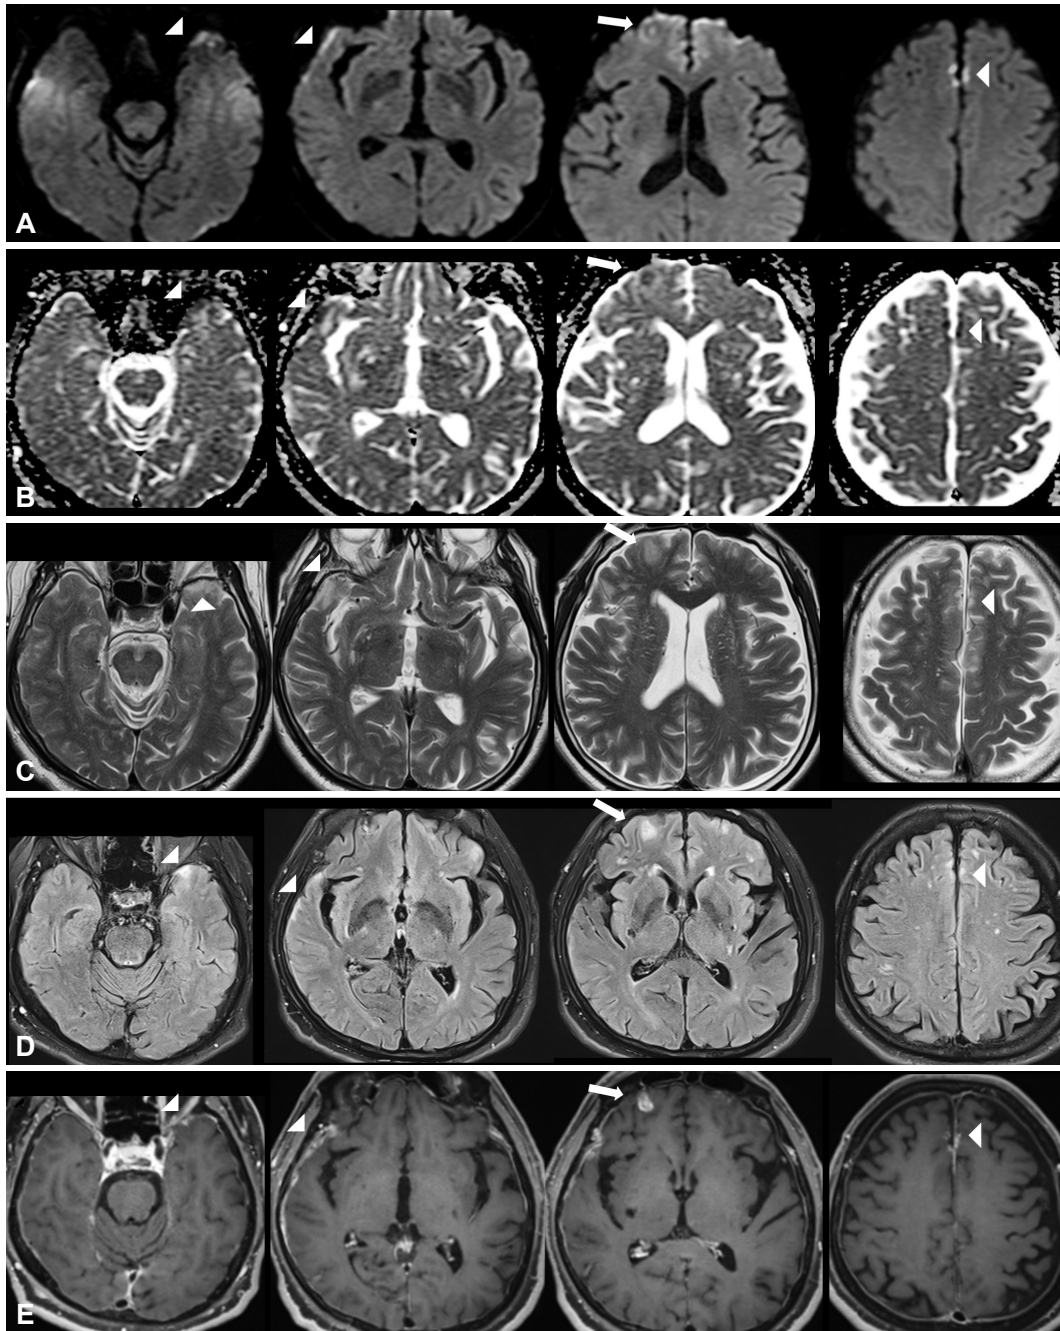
Diffusion-weighted images (A) obtained 6 days after symptom onset reveal multiple hyperintensities in the left temporal pole, right temporal convexity, interhemispheric fissure (arrowheads from left to right), and right dorsolateral prefrontal cortex (arrow). These lesions appear hypointense on the corresponding maps of the apparent diffusion coefficient (B). T2-weighted images obtained simultaneously with the diffusion-weighted images (C) and fluid-attenuated inversion-recovery images (D) obtained 1 day later show hyperintensities in the corresponding regions and the adjacent cortices. Contrast-enhanced T1-weighted images (E) show the right frontal tuberculoma (arrow) and pachymeningeal thickening with enhancement along the left temporal pole, right temporal convexity, and falx cerebri (arrowheads from left to right).
